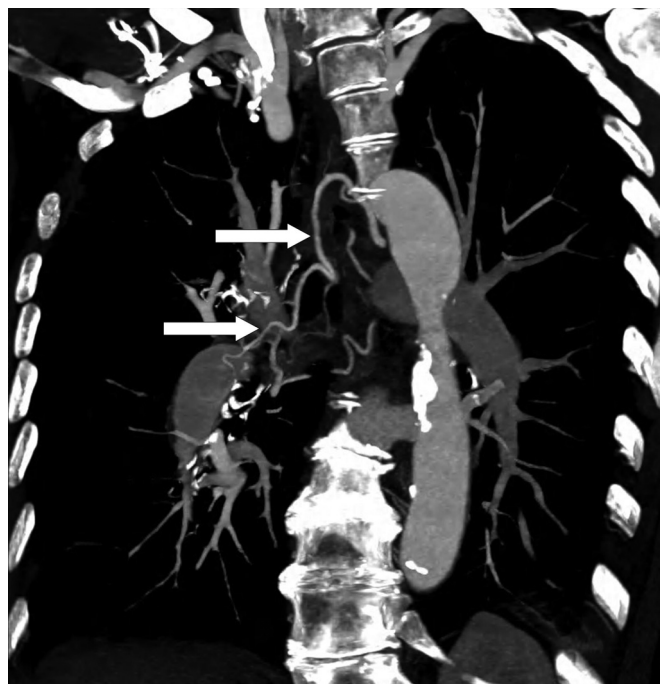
Computed tomography angiography with maximum-intensity reconstruction in the coronal plane showing hypertrophy of systemic bronchial arteries (arrows) in a case of proximal chronic thromboembolic pulmonary disease.
